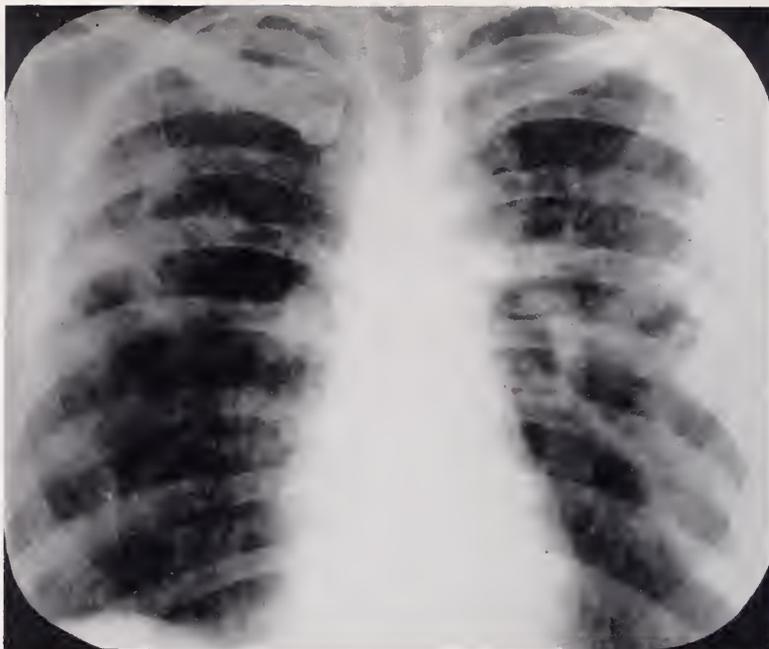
(X-ray). *J. M.* March 7, 1952. Chest x-ray on admission showing bilateral extensive disseminated active tuberculosis.
